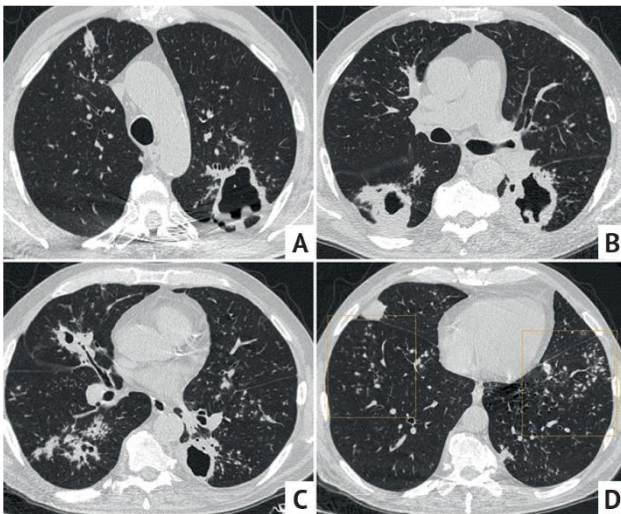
Axial chest CT images of 44 y.o patient with pulmonary tuberculosis. In the upper lobe, as well as in S6 on the left, there are irregular caverns with bay-shaped contours without content, walls is quite thick, there are no fibrosis around. There are nodules of bronchogenic dissemination (boxes) in all parts of the lungs (A–D)
